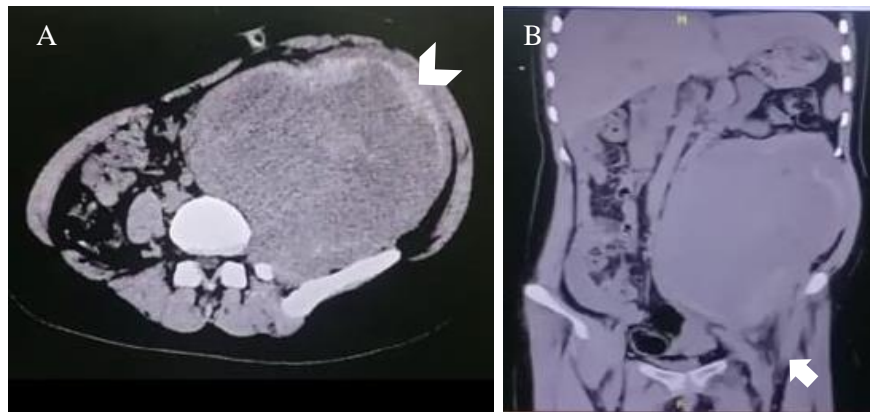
Abdominal computed tomography (CT) findings. Horizontal (A) and coronal (B) views by CT before surgical debulking (14/09/2020). Abdominal CT showed a left psoas abscess (white arrow) suggestive of TB that extends to the retroperitoneal and pelvic cavities (arrowhead), pushing the left kidney and left ureter cranially as well as abdominal aorta and left iliac artery to the right.
